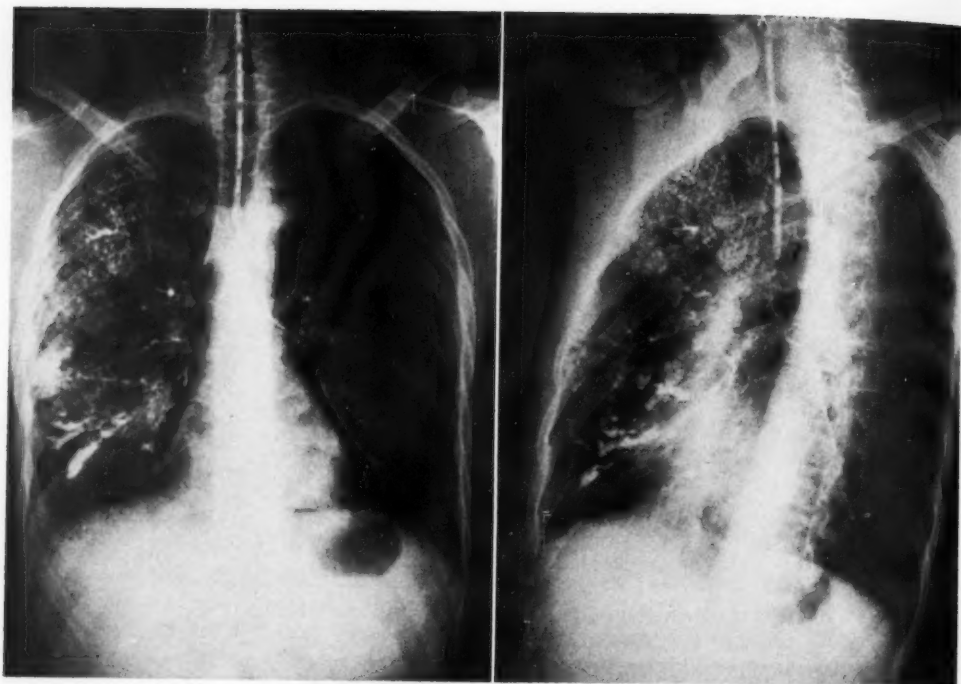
Postero-anterior and oblique roentgenograms, Sept. 1, 1955.
